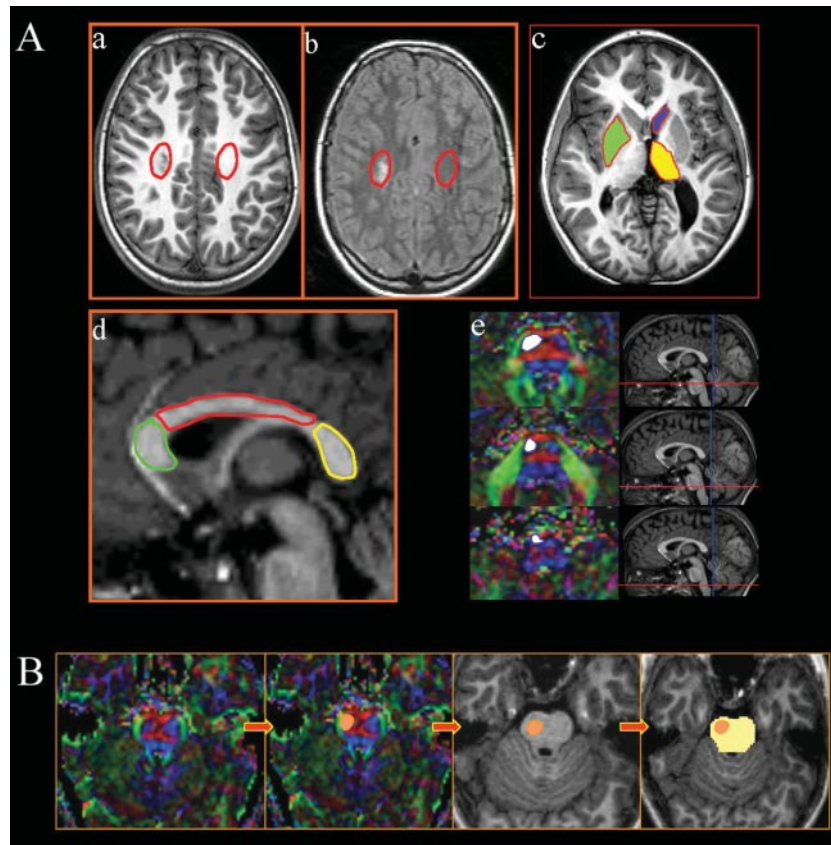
(A) ROI analysis of diffusion parameters. The locations of the ROI marked for the analysis of various diffusion parameters (see text), are shown at the sites of primary periventricular lesion (red) (a and b), deep grey matter nuclei (yellow, green, blue) (c), the different regions of the corpus callosum (green, red, yellow) (d) and the pyramidal tract in the brainstem at different levels (white) (e) (note the corresponding sagittal reference images). All the sites were studied bilaterally except the corpus callosum. The ROI were placed on the coregistered anatomy sections in the case of primary sites, deep grey matter and the corpus callosum and on the colour maps for the CST in the brainstem. Note also that the corresponding axial FLAIR image (b) was used for better delineation of the primary site in subtle lesions. (B) Cross-sectional area ratio measurements of pyramidal tract in upper pons. The cross-sectional area of the pyramidal tract in the upper pons was marked at first on the axial colour map and then superimposed on the corresponding anatomy sections (orange). The total cross-sectional area of the pons at this level was also measured (yellow) and a ratio was calculated. This was repeated for the contralateral pyramidal tract.
